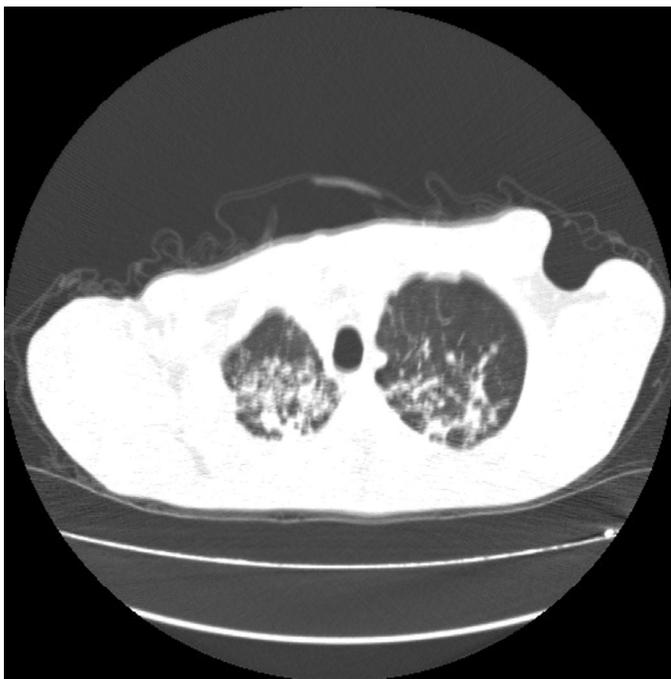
Thoraco-abdominal computed tomography image showing pulmonary tuberculosis
